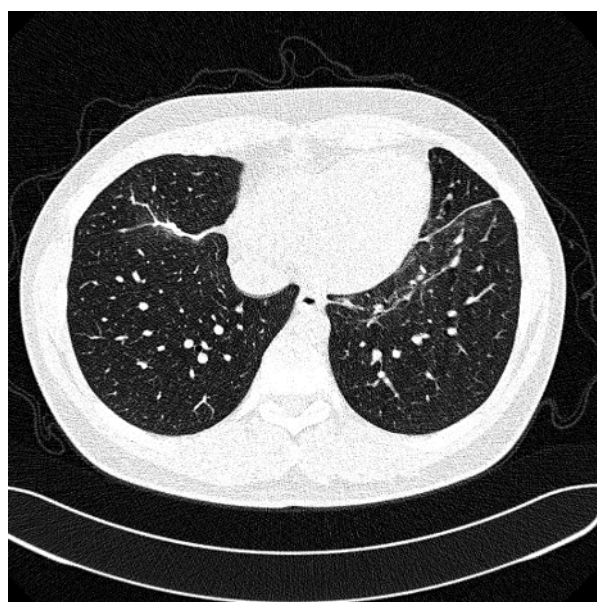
CT — after three months near — complete regression of lung consolidations
